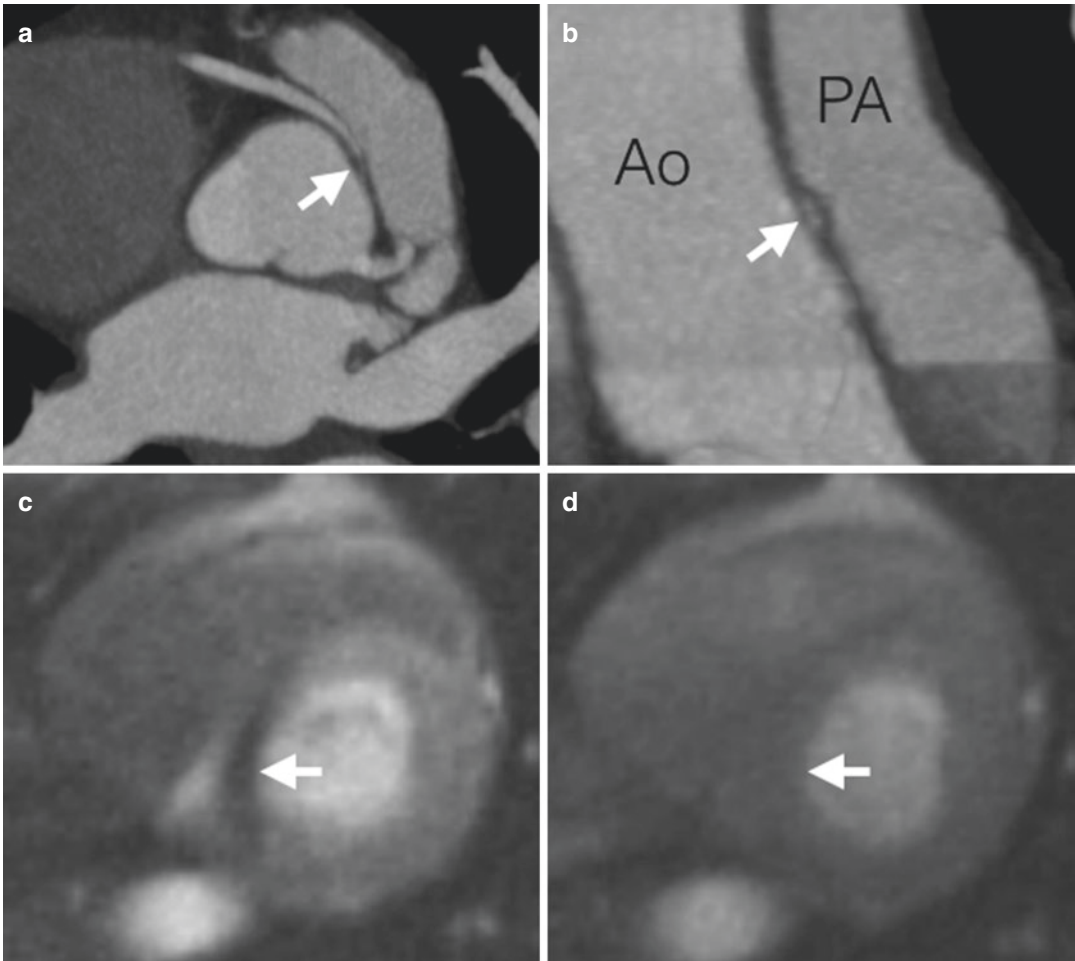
Anomalous RCA from the left coronary sinus with evidence of ischemia. (a) Axial slice from gated CT at the level of the aortic root demonstrates that the RCA arises from the left coronary cusp and has a slit-like origin in its proximal portion (arrow). (b) Sagittal oblique reconstruction from gated CT to show the relationship between the aortic root (Ao) and main pulmonary artery (PA). The slit-like ostium can be appreciated in cross section (arrow)
